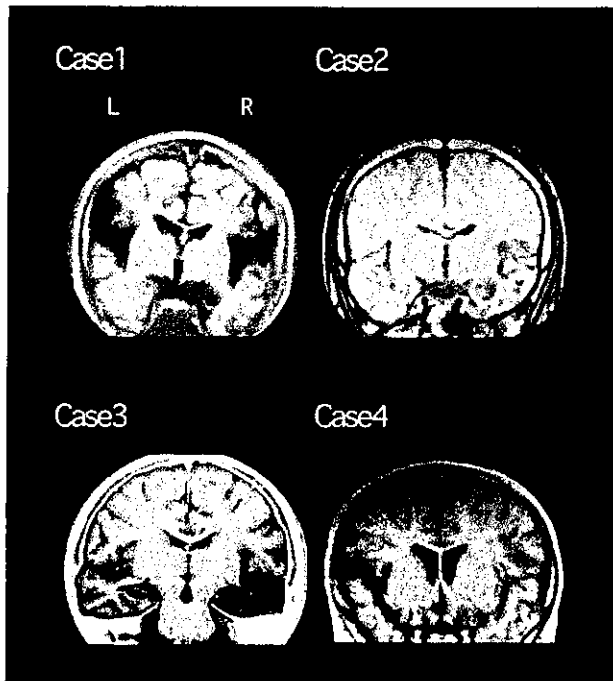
Brain MRI scans of the four cases after herpes encephalitis. Note the bilateral lesions in the superior temporal gyrus, including the auditory cortex.
